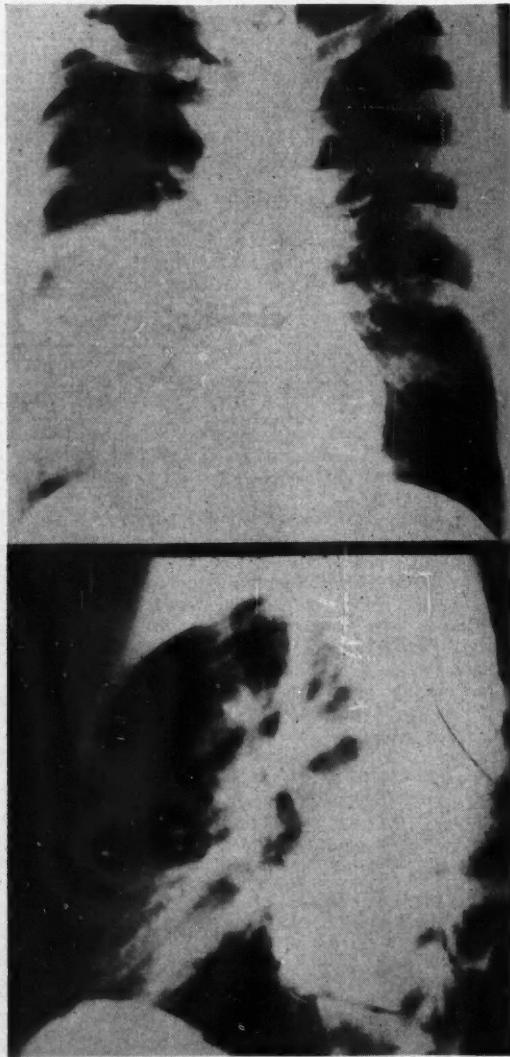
X-ray films of chest, posterior-anterior and lateral, November 15, 1950. Consolidation in posterior portion of right lung field involving the superior portion of the lower lobe.
